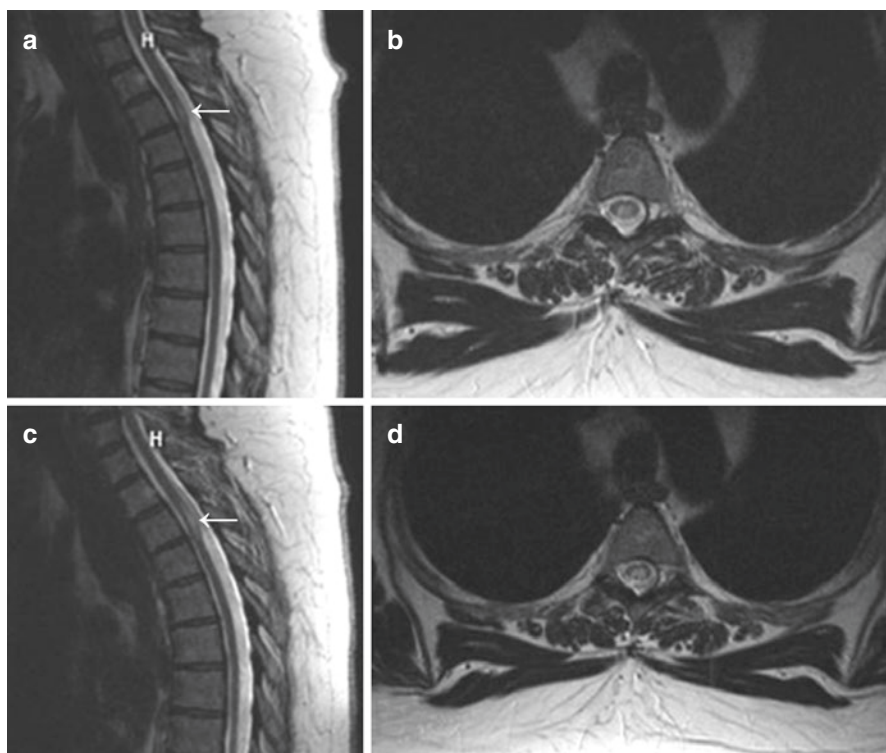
Imaging of a 61-year-old female patient with diabetes and worsening gait. The patient was followed for years with an intramedullary lesion at T1. (a) Sagittal T2-weighted MRI of the thoracic spine showing the hyperintense intramedullary lesion at T1 (arrow). (b) Axial T2-weighted MRI of the thoracic spine at the same level. (c) Six-year follow-up showing growth of the lesion at T1 in sagittal T2-weighted MRI of the thoracic spine (arrow). (d) Axial T2-weighted MRI of the thoracic spine
